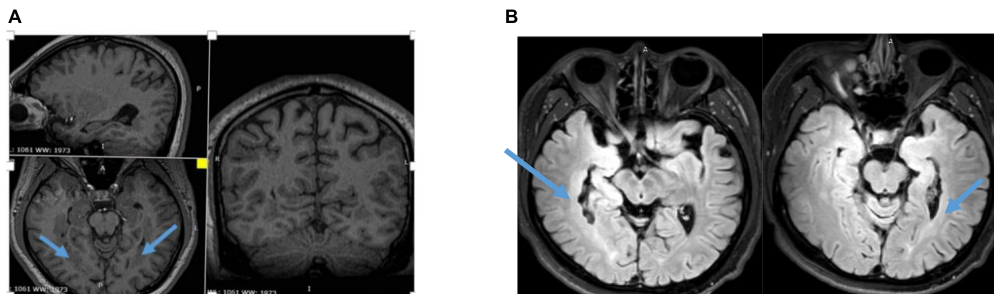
(A) Three-dimensional (3D) MRI showing bilateral periventricular heterotopia and overlying polymicrogyria. (B) T2 Flair of MRI showing asymmetry bilateral periventricular heterotopia and overlying polymicrogyria.
